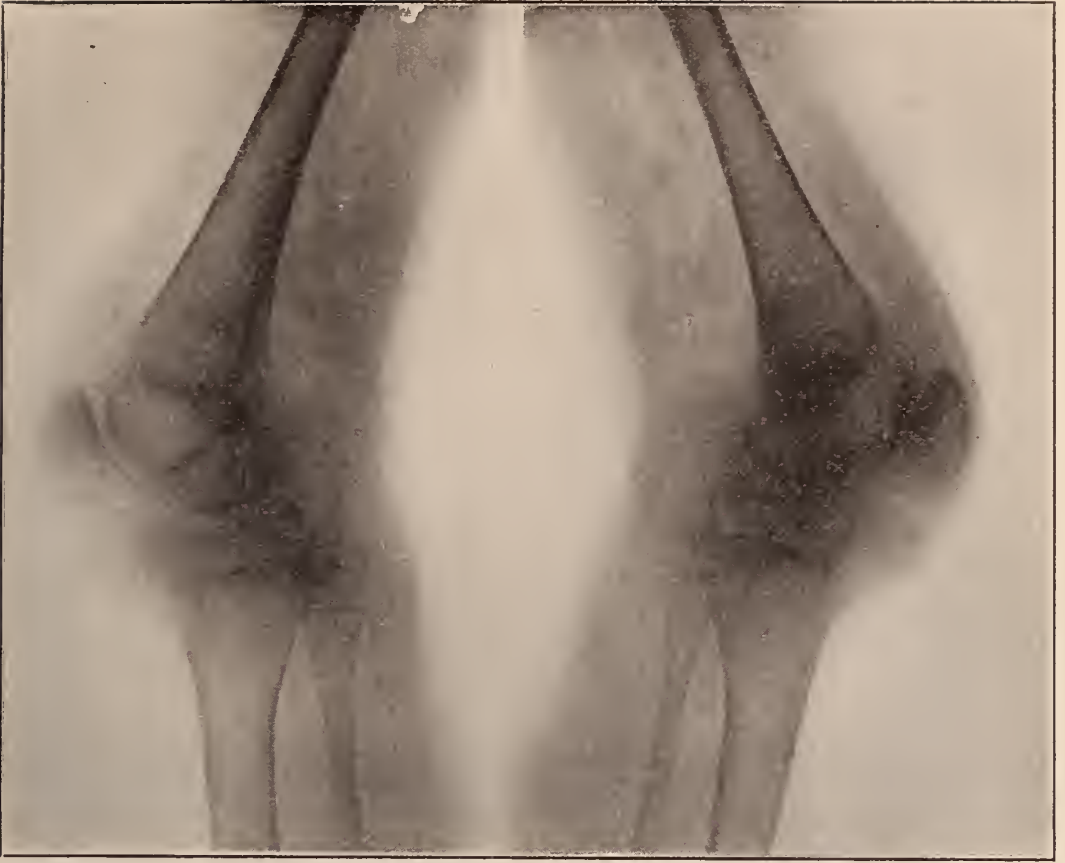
Skiagram of Case 1, showing the typical X-ray picture of the right and left knee joints in Still's Disease. The swelling about the joint can be clearly seen. The bones and cartilages of the joints are normal.
